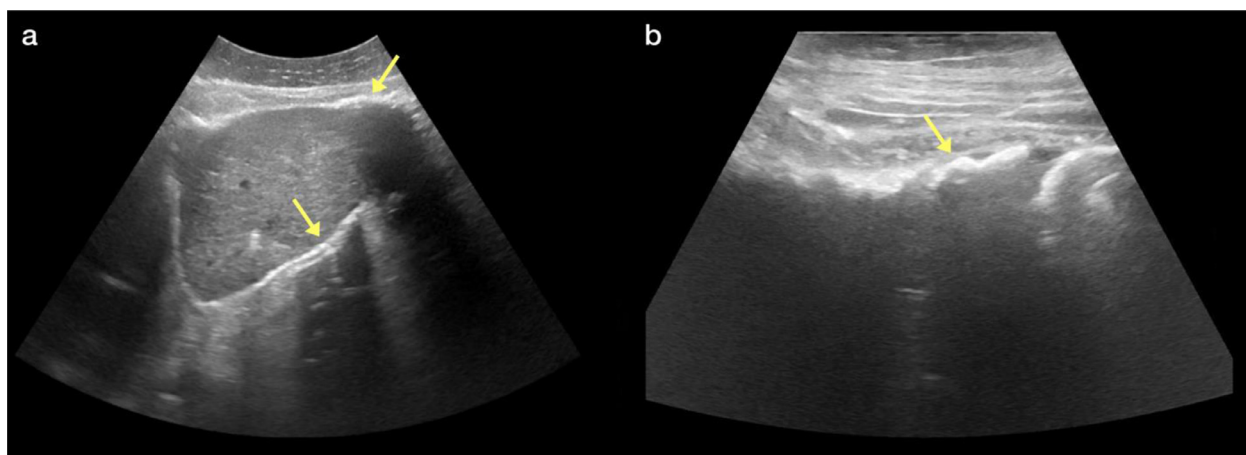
Abdominal ultrasound (US) shows scattered curvilinear hyperechoic areas with acoustic shadowing (arrows), for example along the posterior hepatic margin (a) and overlying several bowel loops (b).
